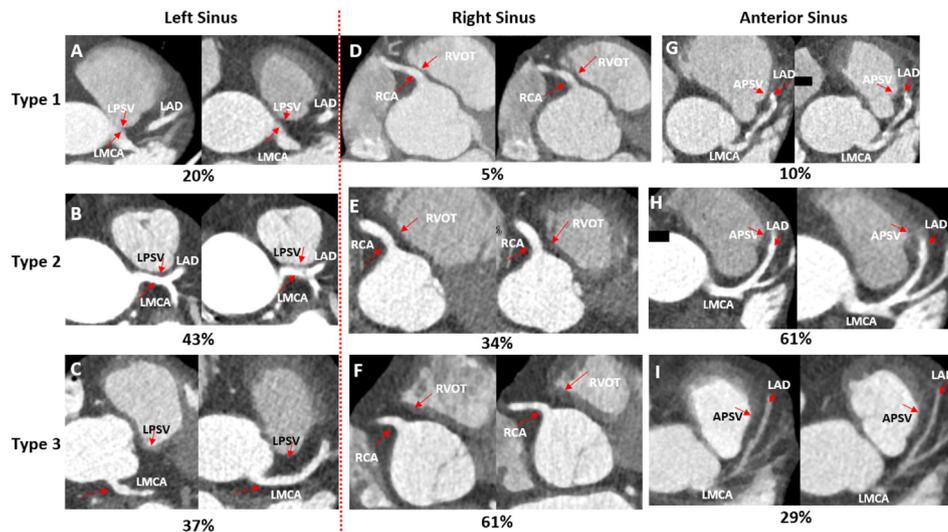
CT Axial plane images (left panel: diastolic phase; right panel: systolic phase). A–C) Types of LMCA-PSV anatomic relation and their prevalence. D, E, F) Three relationships between the RCA and RVOT in ≤ 2 mm, 2–5 mm and > 5 mm and their prevalence, respectively. Three relationships between APSV and LAD in G) ≤ 2 mm, H) 2–5 mm and I) > 5 mm, and their prevalence. LMCA = left main coronary artery; LAD = left anterior descending artery; RCA = right coronary artery; LPSV = left pulmonary sinus of Valsalva; APSV = anterior pulmonary sinus of Valsalva; RVOT = right ventricular outflow tract.
